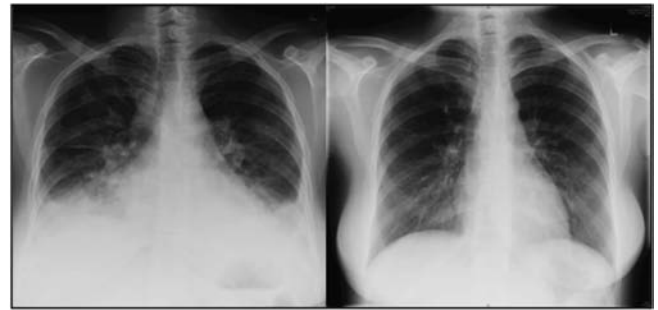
Posterior–anterior chest roentgenograms. The measured systolic pulmonary artery pressure was 43 mm Hg (left). After repair (right), all symptoms resolved.
